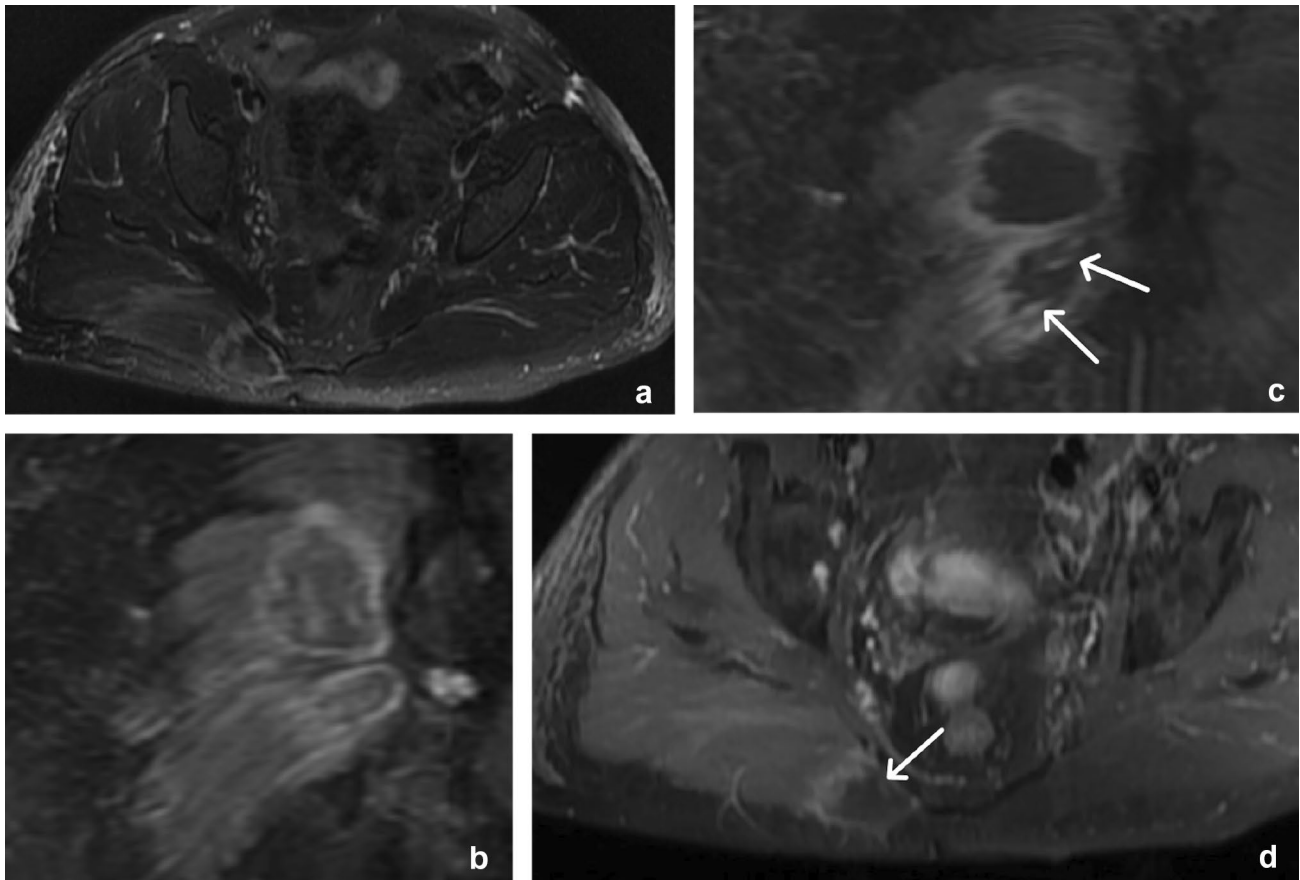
47-year-old male with right gluteus maximus muscle myonecrosis. Axial T2 fat-saturated (a) and coronal STIR (b) MR images demonstrate heterogeneously increased signal, although less than fluid intensity, within and around the lesion. Coronal (c) and axial (d)
